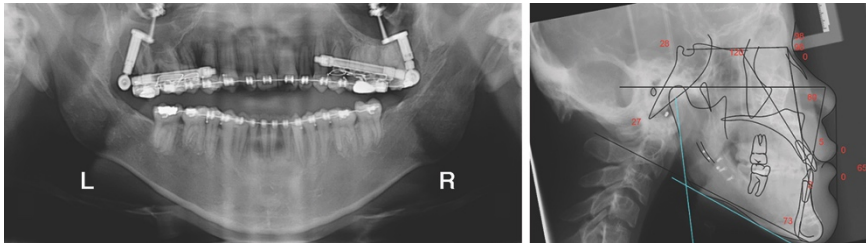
A: Post-surgical pantomograph that shows internal distractor. B: Post-surgical lateral cephalometric x-ray with tracing.
